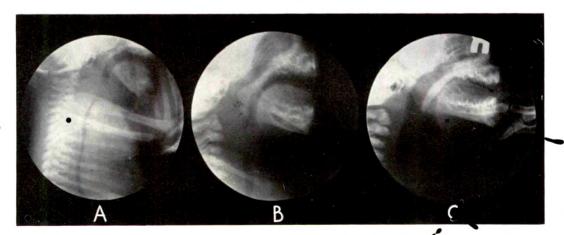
Case 1. A, the pronounced retropharyngeal and retrotracheal swelling produces almost complete tracheal compression in a six weeks' old infant. B, six days after beginning roentgen therapy the swelling is regressing and the tracheal compression has disappeared. C, six weeks after therapy the retropharyngeal space is normal.
